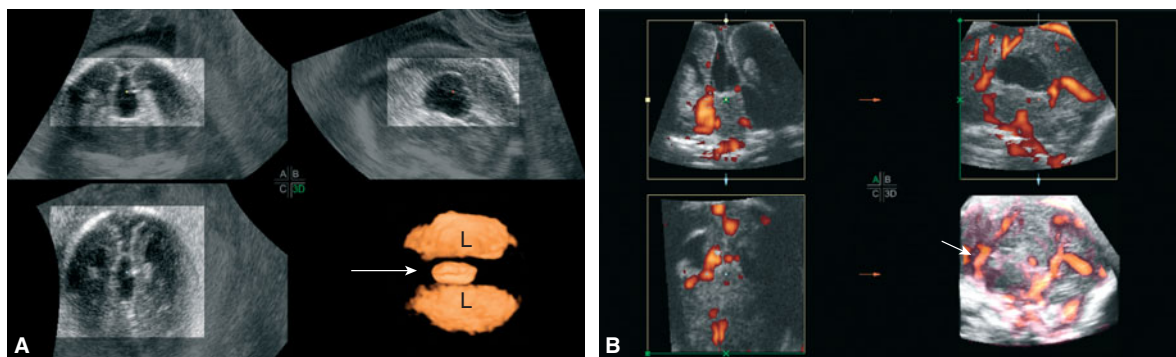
Interhemispheric arachnoid cyst at 21 postmenstrual weeks affecting the corpus callosum. (A) Three-dimensional (3D) orthogonal planes: coronal (box A), sagittal (box B), axial (box C). Box D displays inversion rendering of the lateral ventricles (L) and the arachnoid cyst (arrow). (B) 3D power Doppler study. The planes are the same as in Figure 11-6A. Box D displays the short pericallosal artery (arrow).
